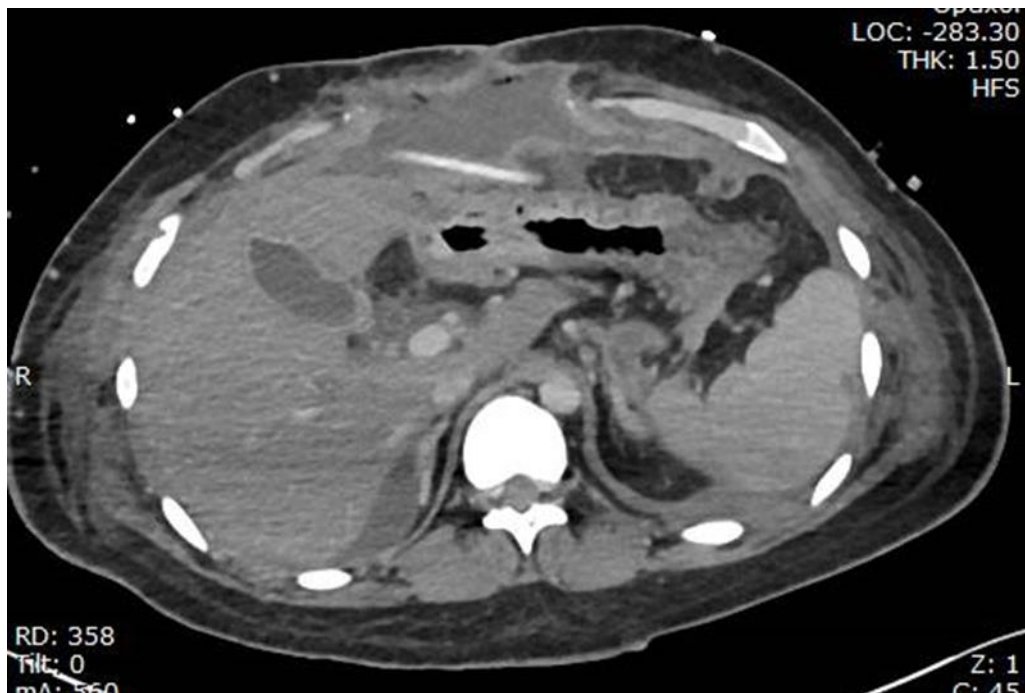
Contrast enhanced CT scan one week later shows omental collection about 110.0 ml. Regression of other collections.
